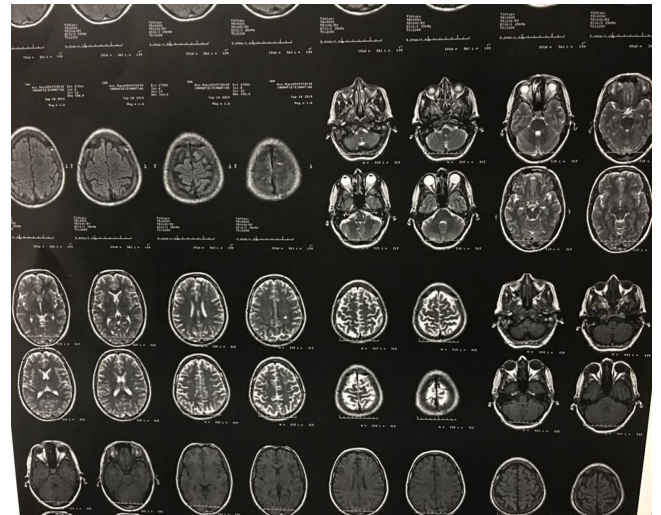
Normal MRI findings
